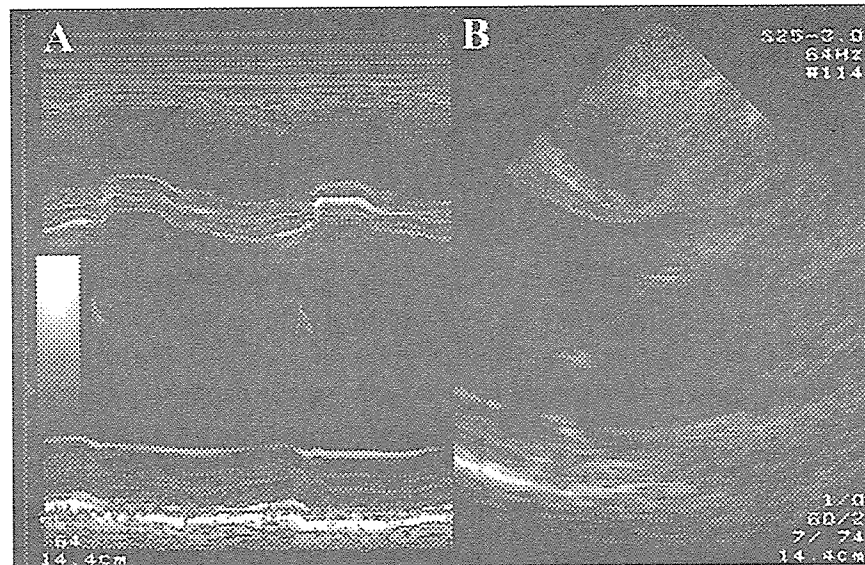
Echocardiography at the age of 27. (1997.1.24)
